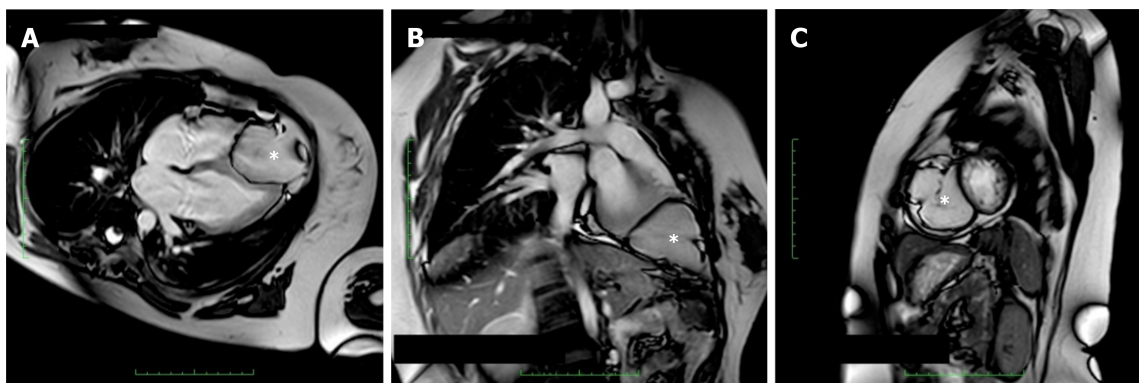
Cine-cardiac magnetic resonance imaging. An encapsulated mass (star) occupying the apical right ventricle. A: Horizontal long axis; B: Vertical long axis; C: Short axis.
